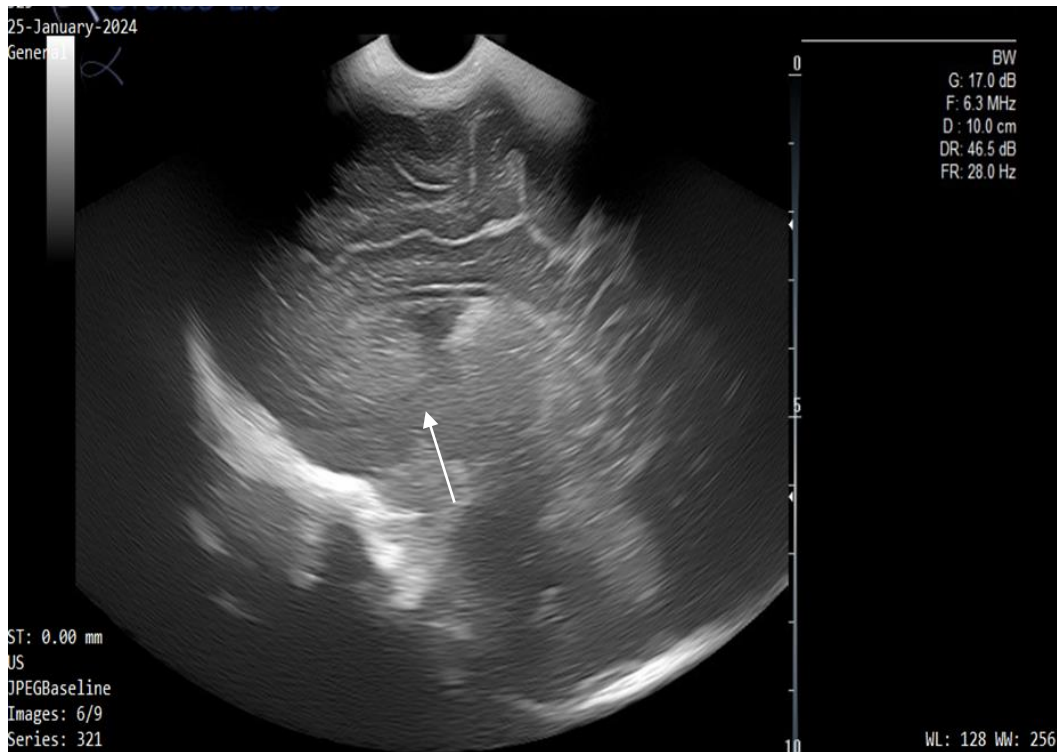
Sagittal plane: female neonate, 40 weeks gestation, 3035 grams, CS delivery due to NRFS, severe HIE. Day cranial ultrasound showed basal ganglia echogenicity, subcortical and periventricular echogenicity.
